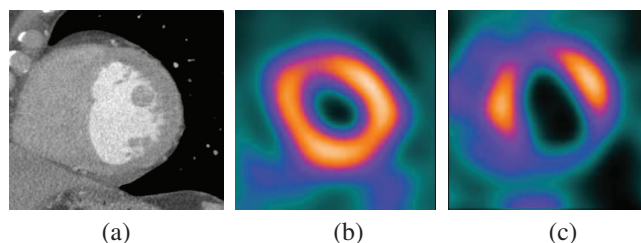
Examples of mid-myocardial short-axis images from CTA and MPS: (a) a CTA image which looks similar for normal and abnormal arteries, (b) a normal MPS image and (c) an abnormal MPS image.
